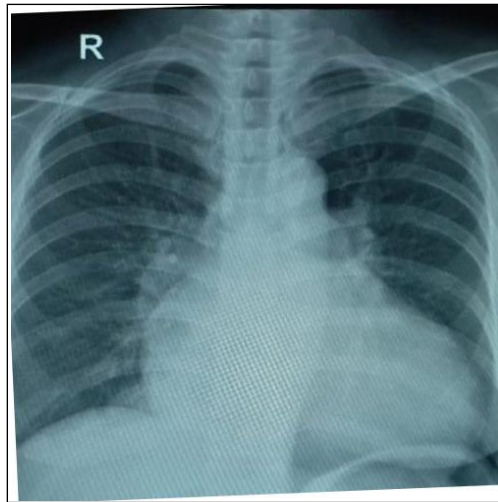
Chest x-ray revealed cardiac silhouette enlargement with minimal pulmonary congestion sign.
